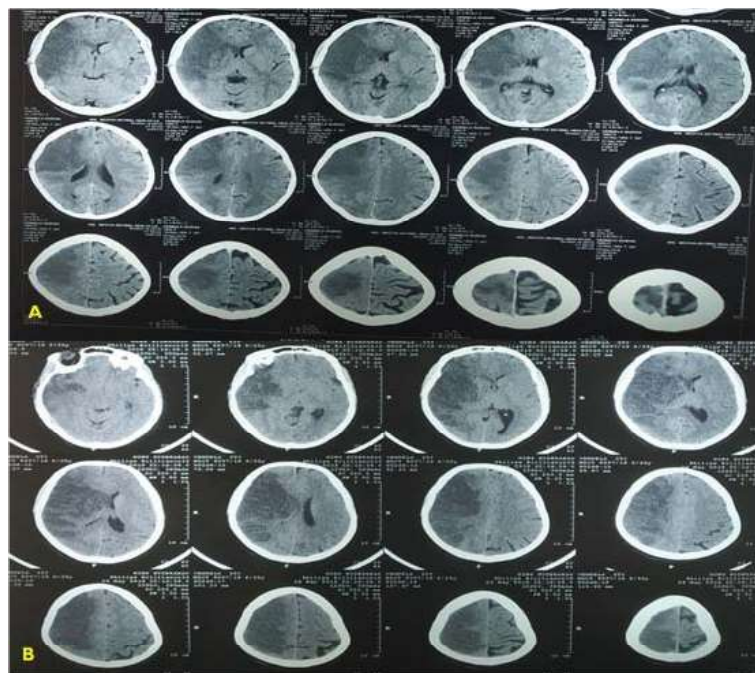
(A) Non contrast CT brain showing large area of hypodensity involving the right fronto-parietal region suggestive of right middle cerebral artery (MCA) territory infarct. (B) Repeat CT showing increase in the size of infarct with effacement of adjacent sulcal spaces.
